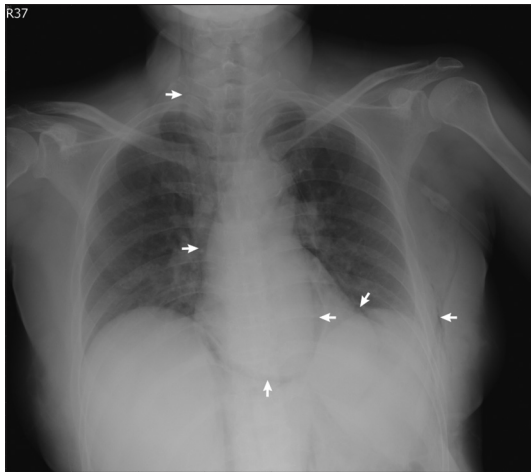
Chest radiograph reveals subcutaneous emphysema over the left chest wall with gas accumulation in the mediastinum extending to the right side of the neck (arrows)
